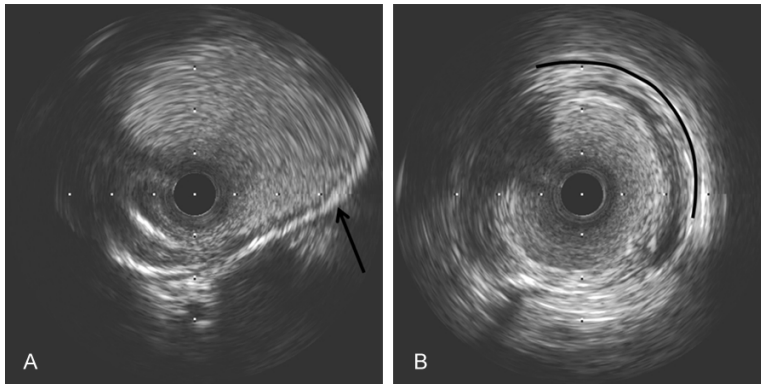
Intravascular ultrasound findings. A. The aneurysm had a three-layer atherosclerotic appearance (arrow) and was classified as a complex plaque. B. We recognized the intra-plaque cavity with the ruptured fibrous cap (solid line) adjacent to the aneurysm.
